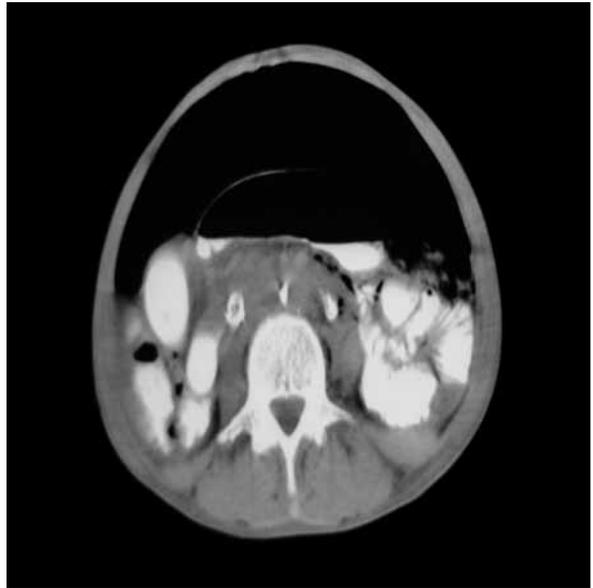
Free intraperitoneal air seen abdominal computed tomography scanning with no extravasation and air in retroperitoneum.
